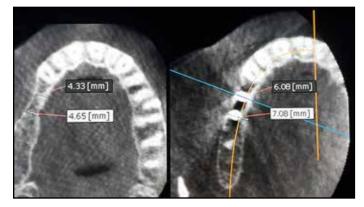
Pre-surgical and post-surgical (6 months) CBCT scan showing increased ridge width and positioned dental implants.
